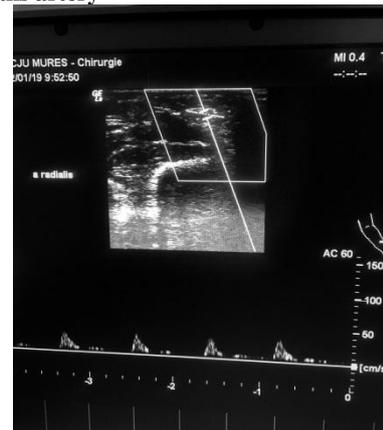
Postoperative Doppler ultrasound showing an open right radial artery
